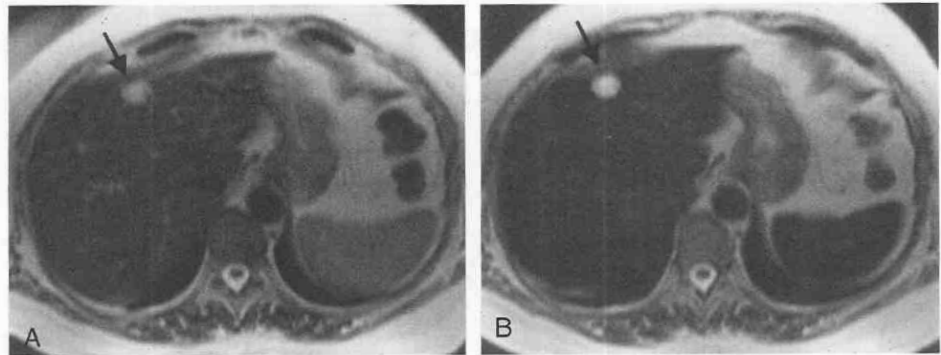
A-E, Hepatocellular carcinoma in a 65-year-old man. The pseudocapsule (arrow) appears dark in the unenhanced T1-weighted (FLASH gradient-echo sequence TR/TE/NSA/FA/TA 84.2/4.1/1/70°/14) (A) (0s) but continuously increases in signal (B-E) beginning with the portal venous perfusion phase (35 seconds).
